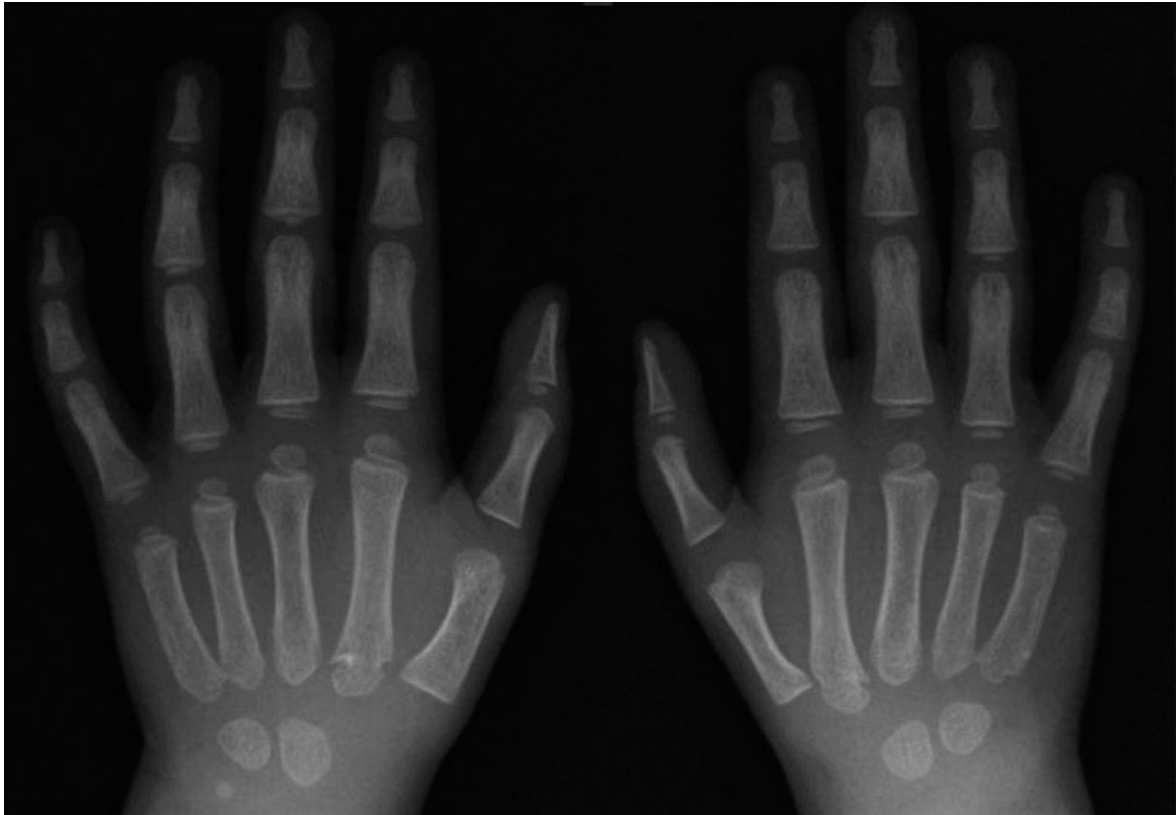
• Plain radiographs of both hands demonstrate a comparatively shorter right thumb with thinner first metacarpal.
